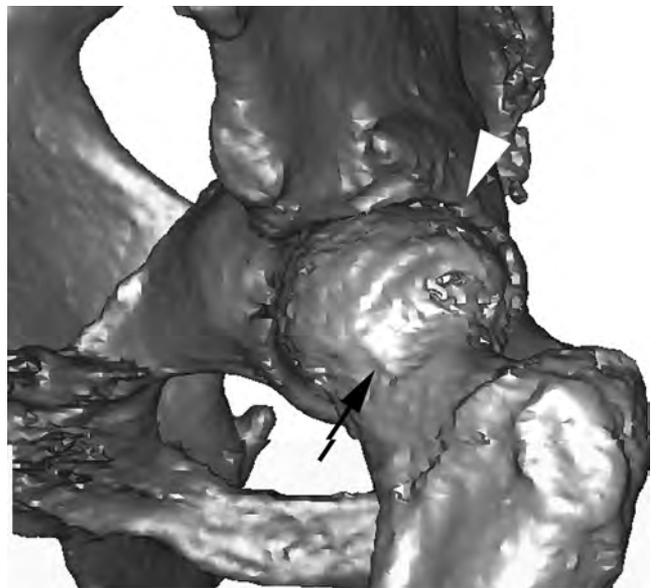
A 3-dimensional computed tomography reconstruction image of the left hip taken during the treatment of the patient's subsequent pelvic injury, 12 months after left hip arthroscopy, indicated improved morphology of both the femoral head/neck (arrow) and the acetabular rim (arrowhead).
